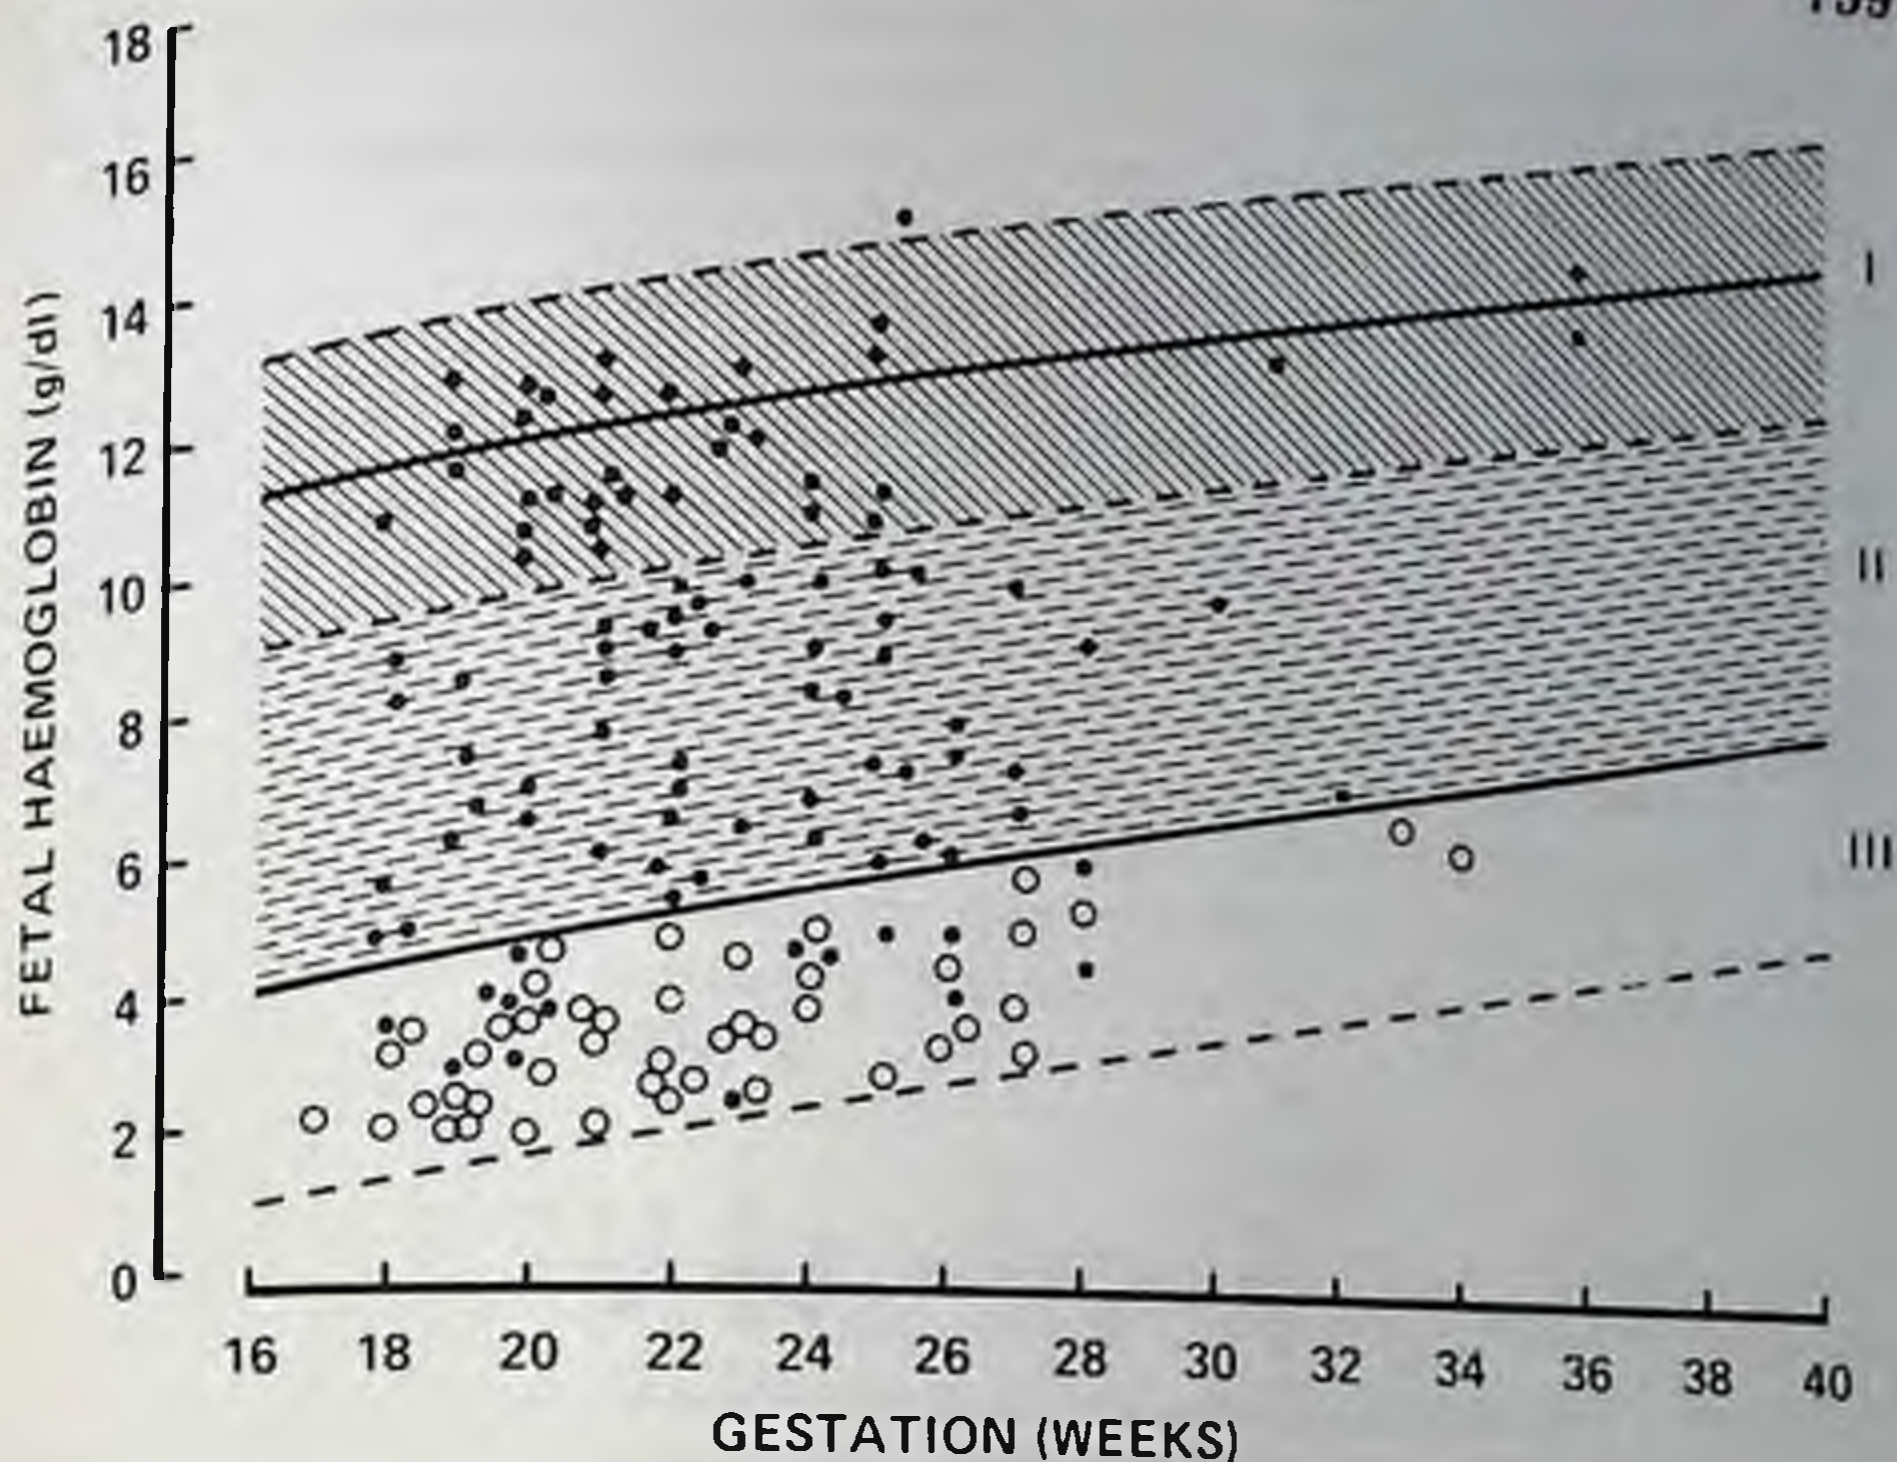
Reference ranges (mean and 95 per cent confidence intervals) for fetal hemoglobin concentration with gestational age from 210 normal fetuses (zone I [shaded area]). The individual values (●) of 154 fetuses affected by maternal red cell isoimmunization are shown. The hemoglobin concentration of all the fetuses with ultrasonic evidence of hydrops fetalis fell within zone III (open circles). When the fetal hemoglobin concentration is less than normal but above the hydropic range it is in zone II (broken lines).
